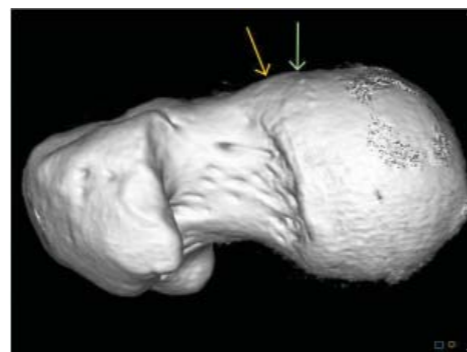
3D surface rendered CT image of the right femoral neck demonstrating a cam deformity at the anterior femoral head neck junction (arrows). The femoral head is also more posterior than normal with respect to the neck, so called posterior offset.
